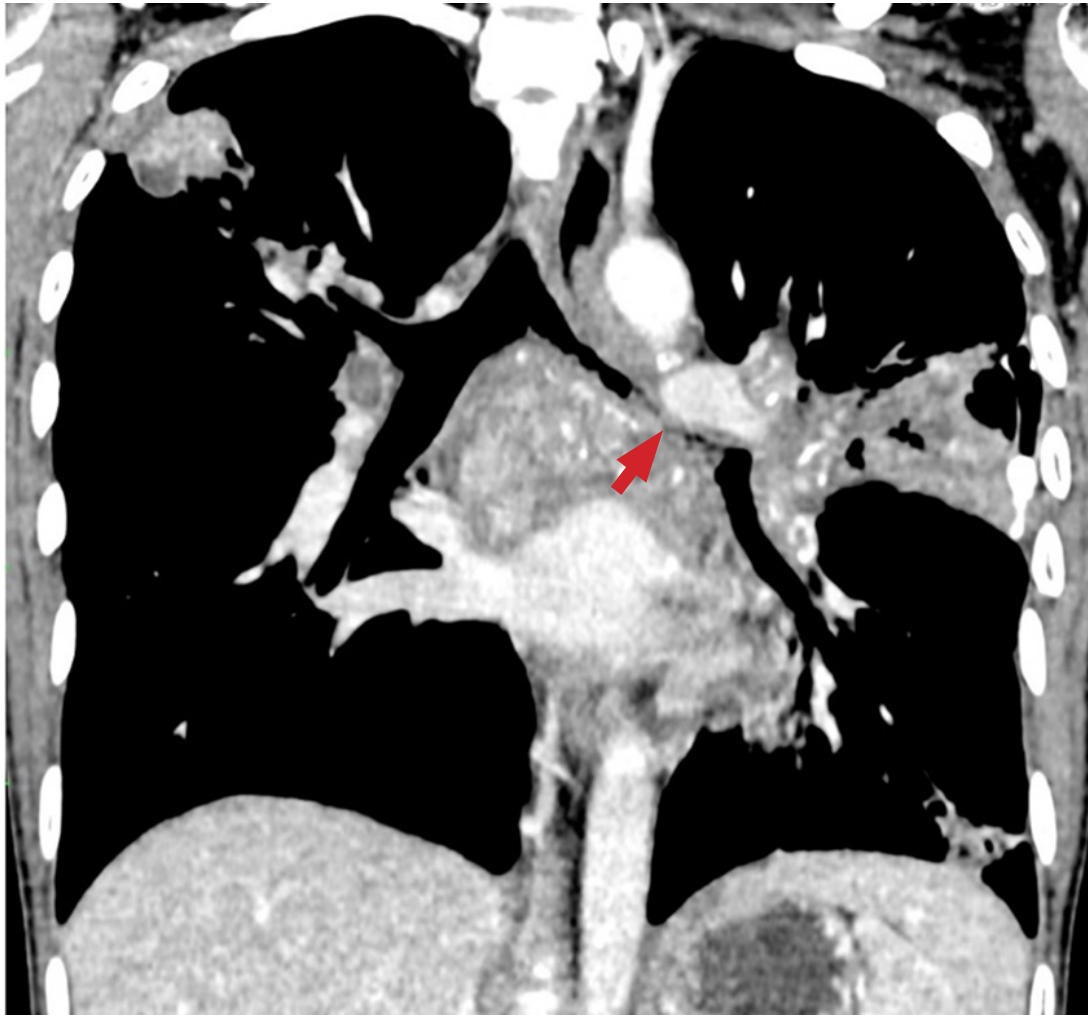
Coronal reconstruction of Contrast-Enhanced CT Thorax in mediastinal window demonstrates airway involvement in active pulmonary tuberculosis. There is significant narrowing of the left main bronchus compared to the right, with near total occlusion distally (arrow). The airway wall is thickened and irregular. There are multiple enlarged hypodense mediastinal and hilar lymph nodes which show calcification. Consolidation is also seen in the right and left lung.
